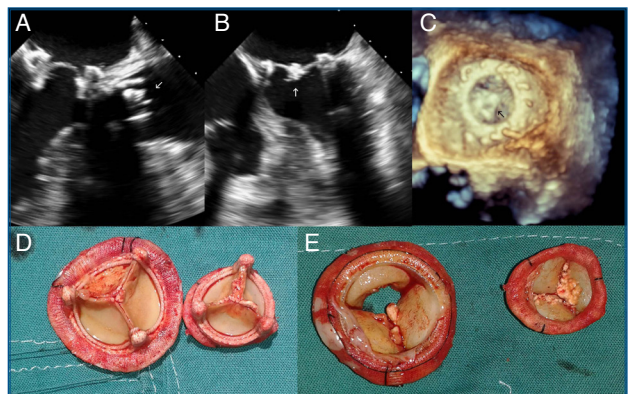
(A-B) Two-dimensional echocardiography images showing lesions adhered to mitral and aortic prostheses suggesting prosthetic valve endocarditis. (C) Three-dimensional transesophageal images of the atrial side of mitral prosthesis. (D-E) Prosthetic valve explanted, showing atypical whitish vegetations.
